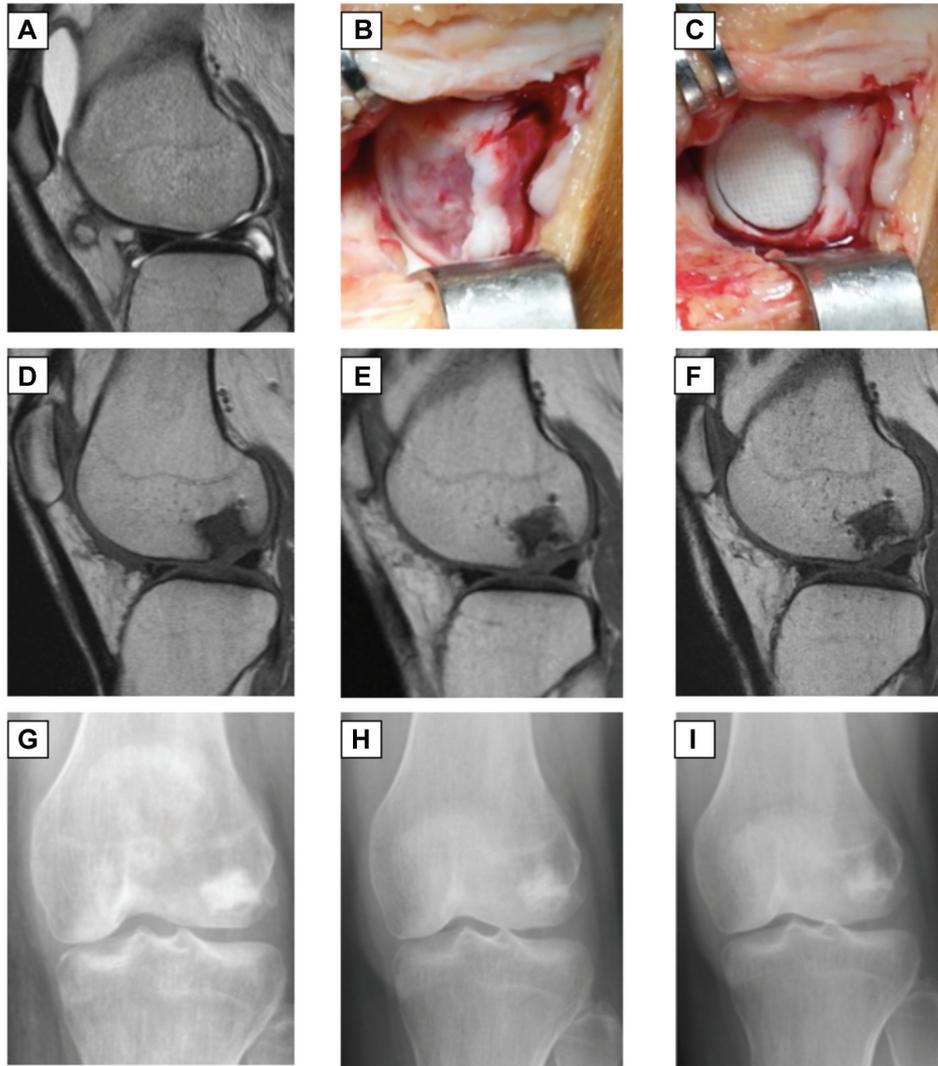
A 32-year-old woman with mild osteoarthritis and a large osteochondral defect on her lateral femoral condyle. The patient was treated with a single aragonite-based implant. (A) Magnetic resonance imaging (MRI) at baseline. (B) Intraoperative view of the defect. (C) Agili-C implantation (note the position 2 mm below the articular surface). (D) MRI at 6 months. (E) MRI at 12 months. (F) MRI at 24 months. (G) Radiograph at 6 months. (H) Radiograph at 12 months. (I) Radiograph at 24 months. Overall Knee injury and Osteoarthritis Outcome Score value improvement: 29.1 at baseline, 50.3 at 6 months, 72.9 at 12 months, 76.8 at 18 months, and 93.6 at 24 months.
